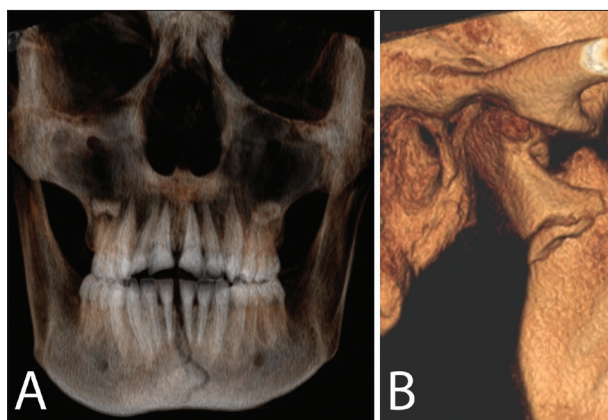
Preoperative cone beam computed tomography (SCANORA® 3Dx, SOREDEX, Tuusula, Finland): a) preoperative postero-anterior radiogram 3D; b) preoperative 3D picture of left and right subcondylar fracture
